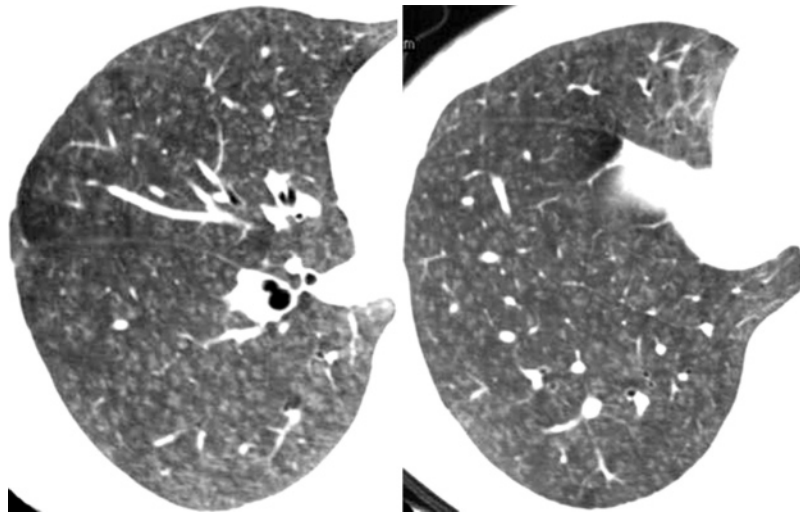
Insidious hypersensitivity pneumonitis. Axial high-resolution CT images depict ill-defined centrilobular ground-glass opacities. (Case courtesy of Cris Meyer, MD, Madigan Army Medical Center, Fort Lewis, Wash.)
